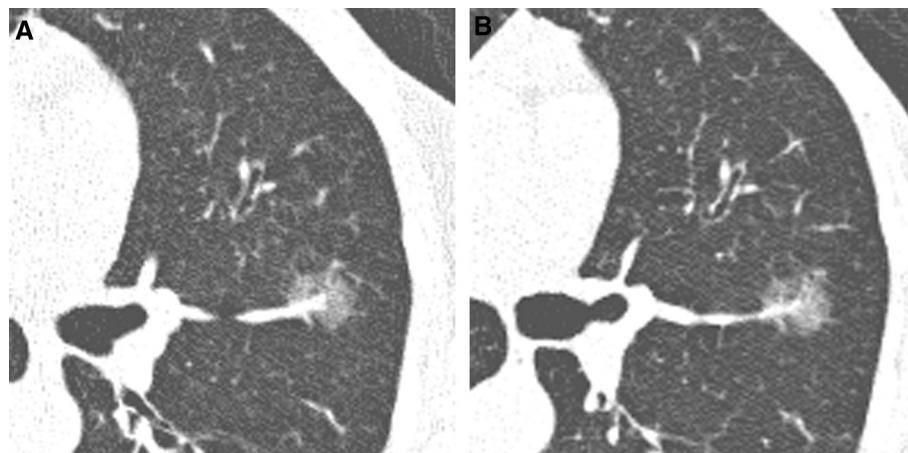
Persistent ground-glass opacity. (A) A 17-mm pure ground-glass opacity on baseline computed tomography (CT) is categorized as Lung Reporting and Data System 3L (indeterminate; requires serial CT). (B) Three months later, the CT shows no change, and the nodule becomes category 4B (likely low-grade adenocarcinoma). This 68-year-old woman underwent microcoil-guided resection. Pathology demonstrated stage IA adenocarcinoma in situ.
